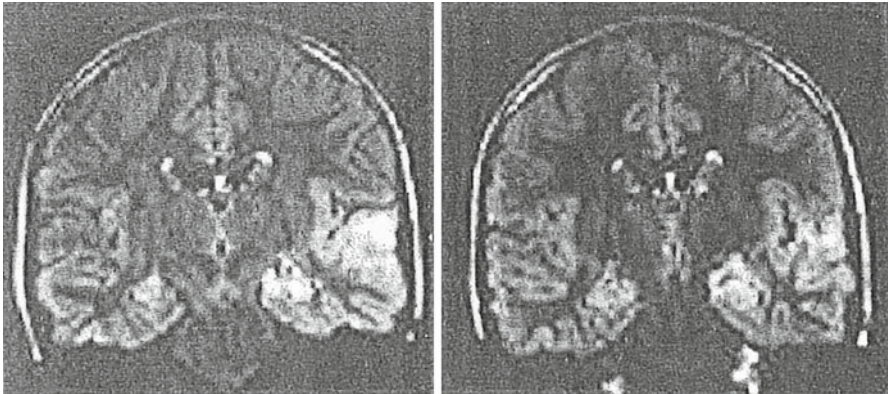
MRI images of Rasmussen's encephalitis. The *left* image is of status epilepticus, the *right* is of more mild seizure activity. With permission of Elsevier-Kuzniecky, R., and Jackson, G. *Magnetic Resonance in Epilepsy*, 2nd ed., 2006
